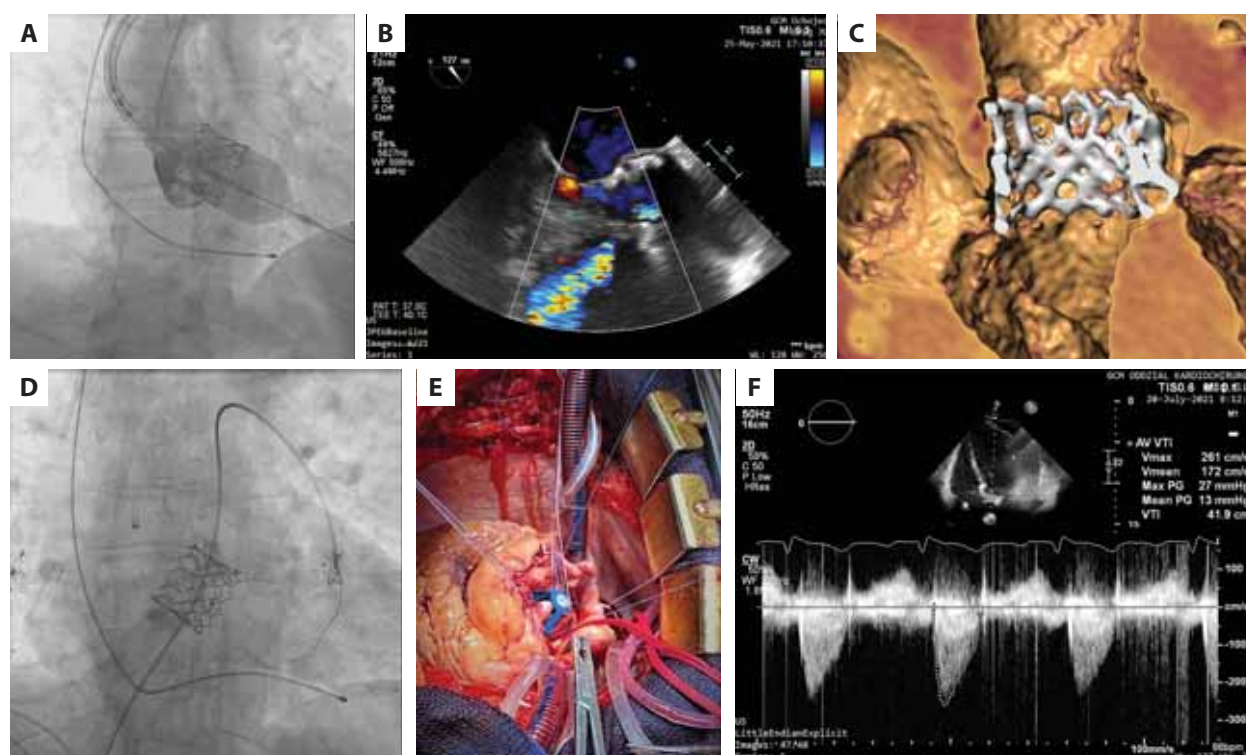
A. Fluoroscopy imaging of transcatheter aortic valve implantation (TAVI) SAPIEN 3 Ultra 29 implantation. B. Echocardiography imaging of jet from the aortic root into the right ventricle. C. 3D imaging of the reconstruction rupture of ventricular septum after TAVI. D. Fluoroscopy imaging of attempts to close the ventricular septum rupture. E. Implantation of the Medtronic Hancock 25 valve. F. Echocardiography follow-up imaging
